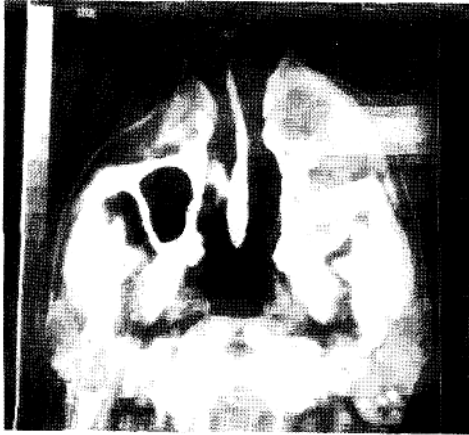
Photograph showing CT scan of the patient with tumor in right antrum extending sublabially by breaching anterolateral wall ( Axial view).
